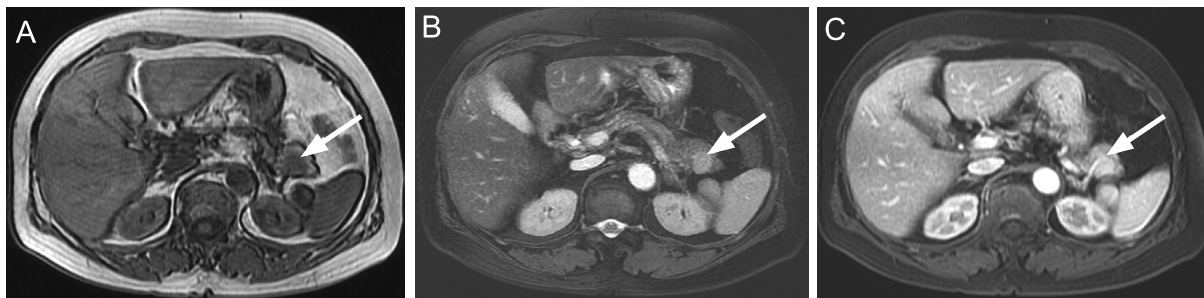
Magnetic resonance imaging (A) Pre-gadolinium axial FSPGR T1-weighted image, (B) pre-gadolinium axial T2-weighted image and (C) post-gadolinium axial T1-weighted image with fat suppression showing a well-circumscribed, homogeneous, enhanced lesion within the pancreatic tail (arrows) matching the signal intensity and enhancing pattern of the spleen in all phases.
